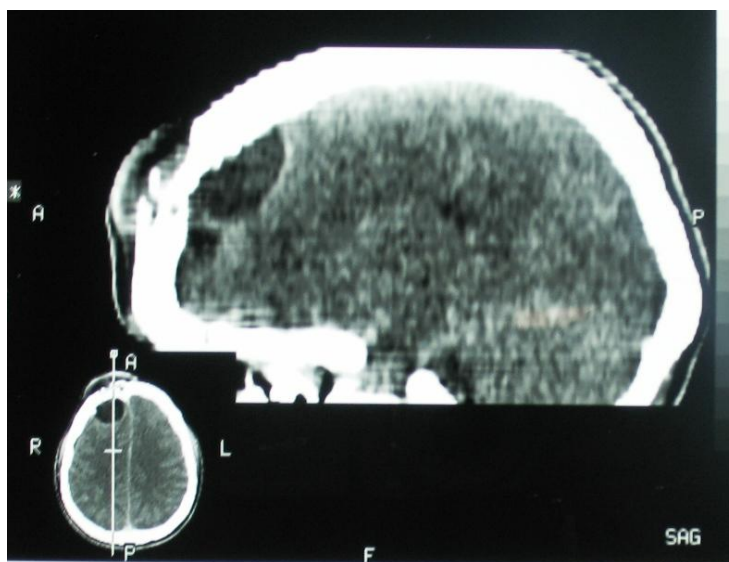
Sagittal CT scan displaying a right frontal hypodense multiloculated cystic lesion associated with swelling of soft tissue and osteolysis of the inner and outer table of the frontal bone.
